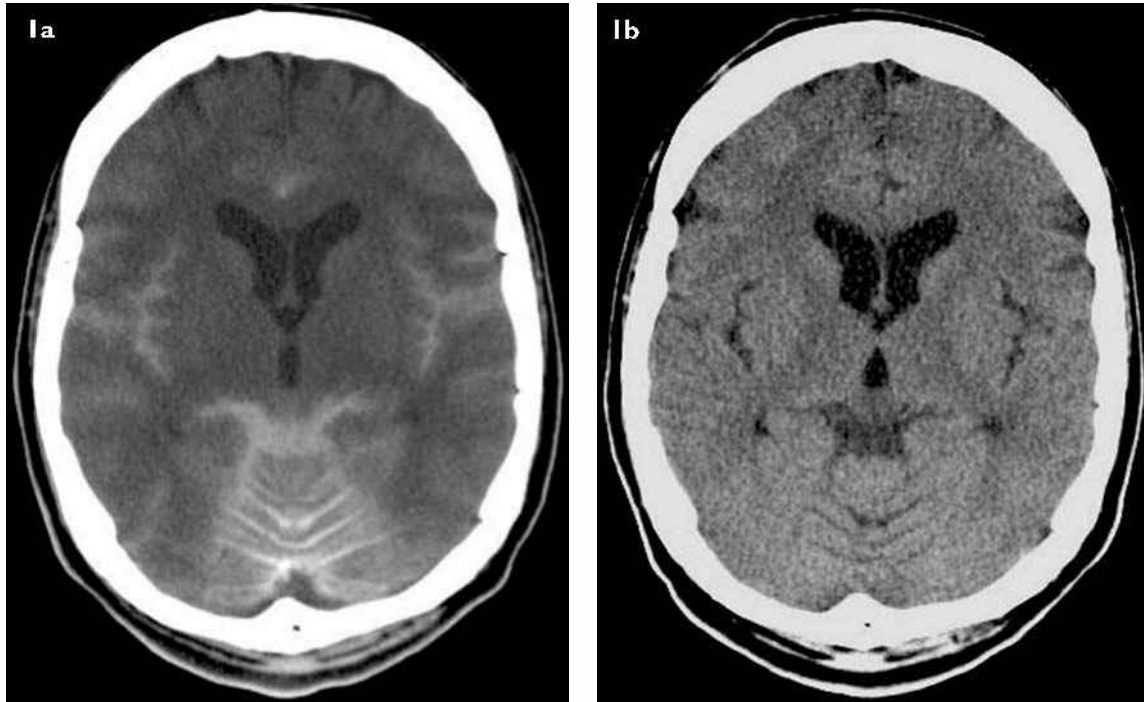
CT images of the brain show (a) widespread hyperdensities in the subarachnoid space, mimicking subarachnoid haemorrhage at eight hours after BIPSS; and (b) complete clearance of the hyperdensities 48 hours later.
